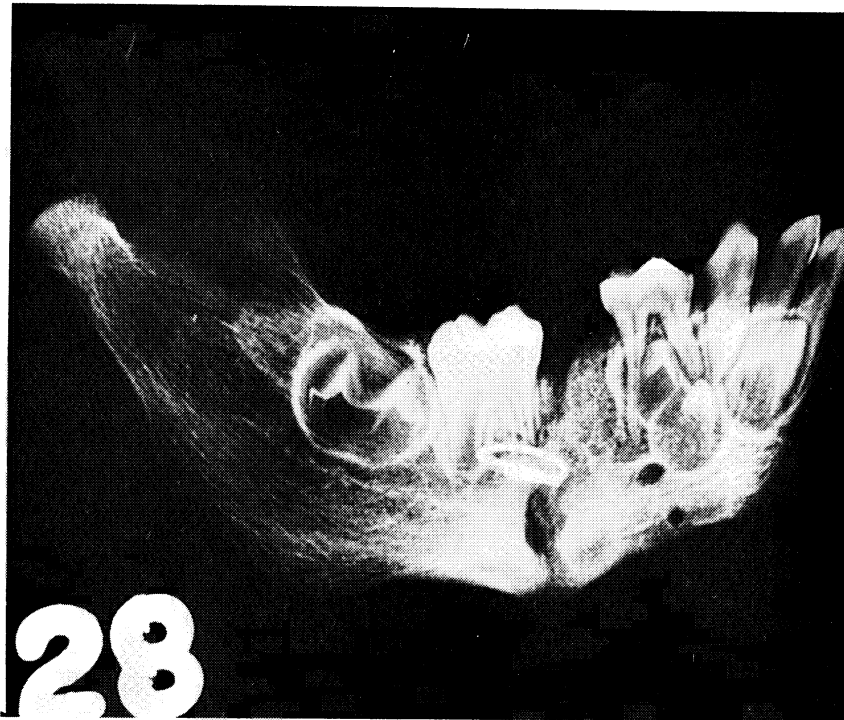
Lateral jaw radiograph of an eight-week clinical union operated intraorally. Note the extreme submandibular callus exostosis.
